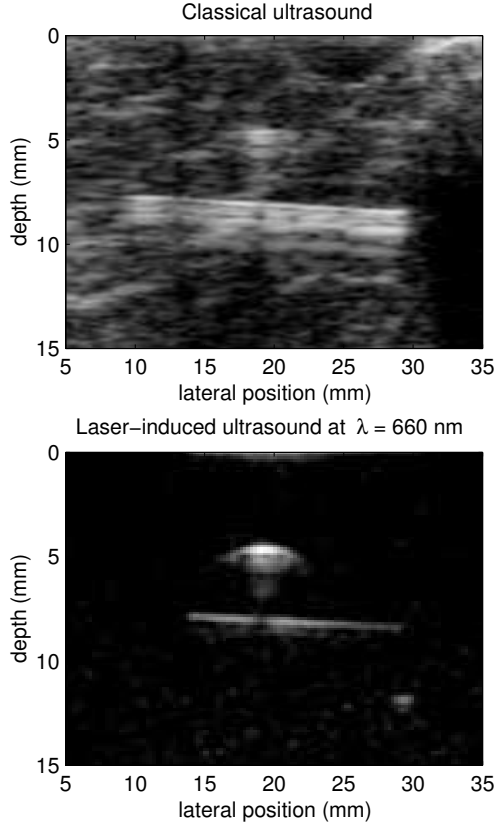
Classical and laser-induced images of a beefsteak containing two crossed 0.5 mm pencil leads. One pencil lead is oriented parallel to the imaging plane at 8 mm depth the other perpendicular to it at 5 mm depth. The laser illumination spot diameter was 1 cm (lateral position 15 mm to 25 mm) and the pulse energy was 8 mJ at a wavelength of 660 nm. The brightness is proportional to the signal intensities in both picture. Both images were reconstructed the same way. Because of the strong optical absorption, the pencil leads show superior contrast on the laser-induced image compared to the conventional ultrasound image. In both images the pencil lead at 5 mm depth produced shading on the lower pencil lead. No averaging was applied.
